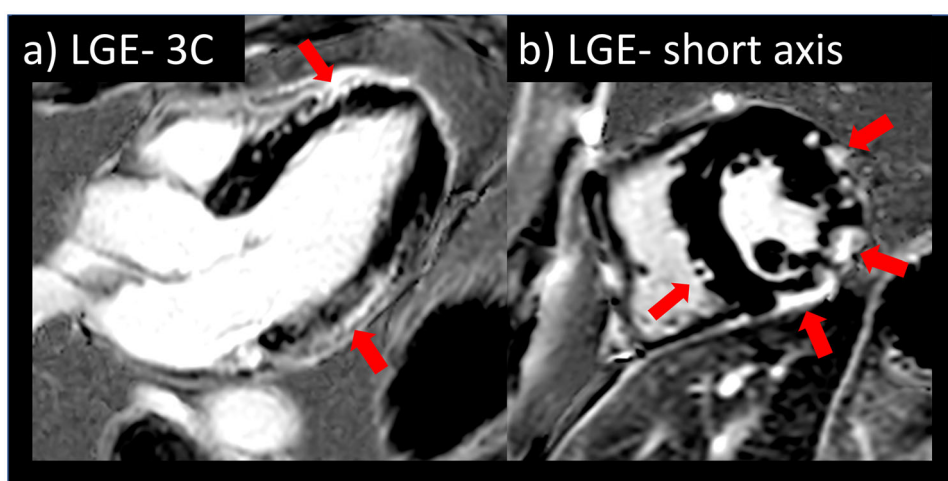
Example of a Class IIa indication for cMR: evaluation of becker cardiomyopathy. A 46-year-old male with Becker cardiomyopathy. Echocardiography was normal. cMR showed normal LV and RV function, but LGE images demonstrated diffuse epicardial LGE, considered as risk factor for arrhythmia.
